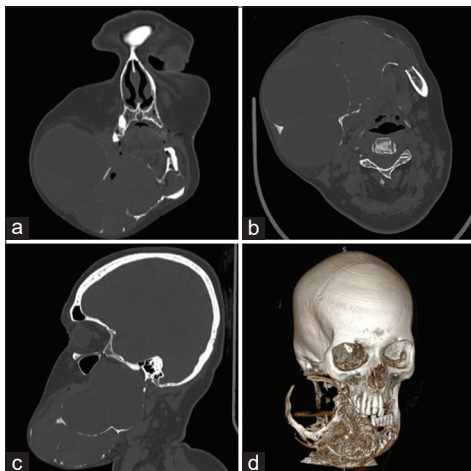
Pre-operative computed tomography (a) coronal view, (b) axial view, (c) sagittal view, and (d) three dimensional reconstruction view
